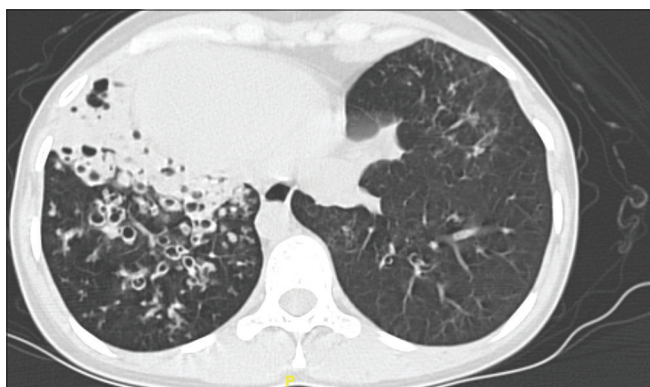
High-resolution computed tomography of the chest showing the presence of bilateral central bronchiectasis with dextrocardia and situs inversus
